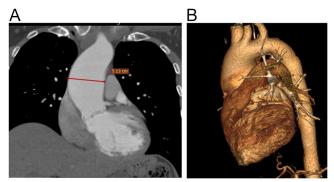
(A) Computed tomography (CT) aortogram coronal image showing a dilated tubular ascending aorta. (B) CT reformatted coronal image showing the dilated tubular ascending aorta.
